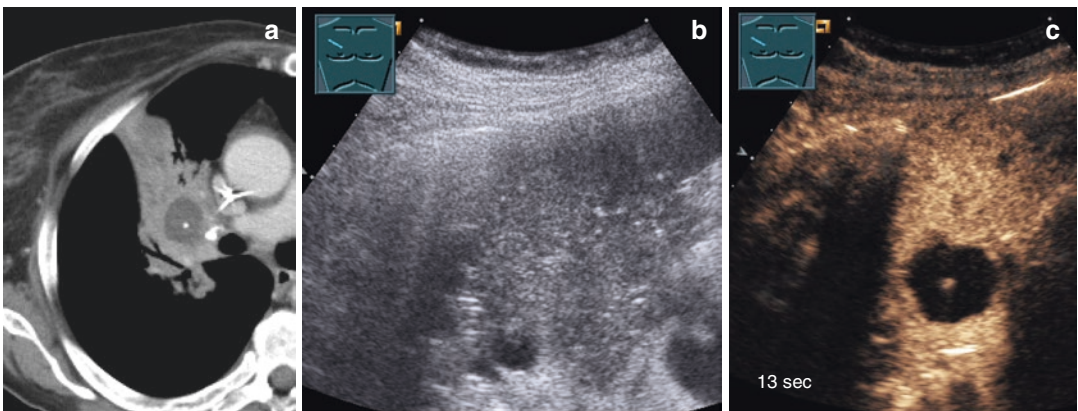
Patient with renal cell cancer (RCC) and evidence of mediastinal tumor and atelectasis of the left upper lobe on X-ray examination (a) and on CT scan (b); B-mode imaging presents a homogeneous echoic
